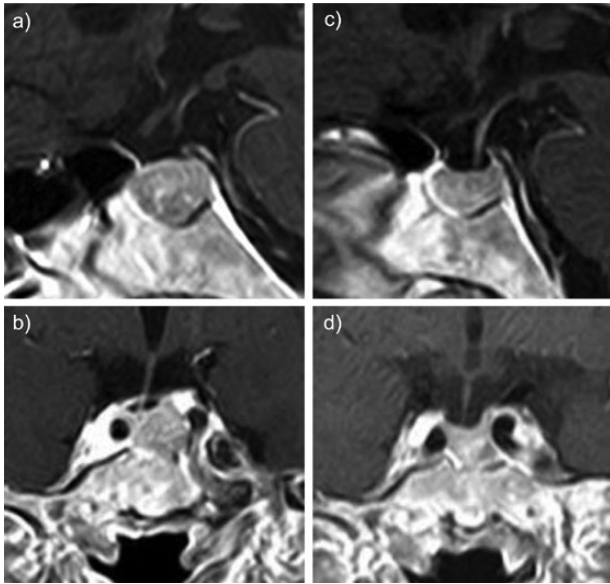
Pituitary magnetic resonance imaging (MRI) before and following metyrapone treatment. The gadolinium-enhanced MRI T1 weighted imaging findings of the sagittal section (a) and coronal section (b) of the patient are shown. Tumor shrinkage after metyrapone initiation is shown in the sagittal section (c) and coronal section (d).
